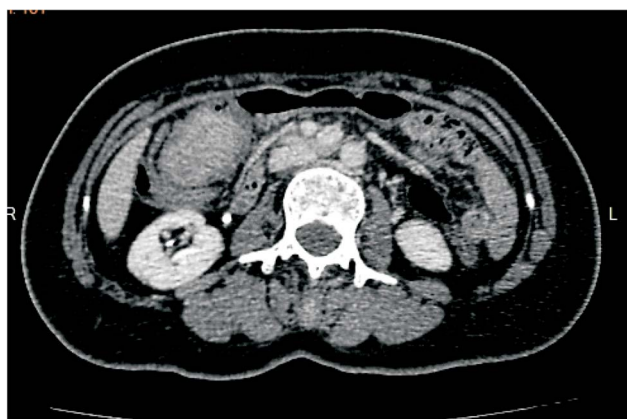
Abdominal CT scan showing a large soft tissue mass in the ascending colon near hepatic flexure with proximal focal colonic-colonic intussusception.
